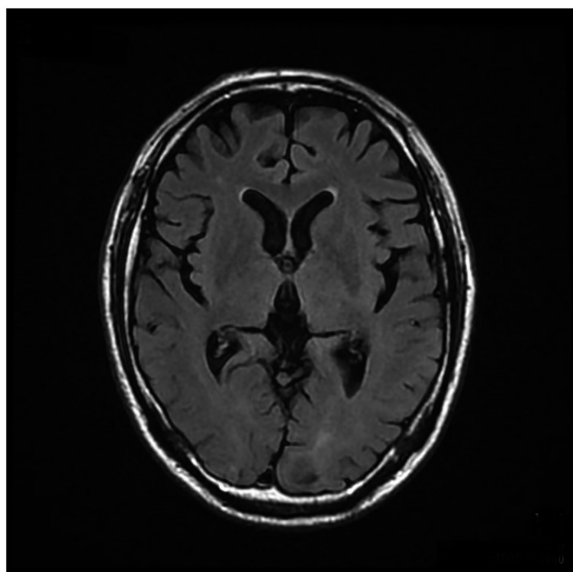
Brain magnetic resonance imaging findings (horizontal section). Cerebral cortex atrophy was not noted. There were no findings of high intensity in the hippocampus region, nor were there findings suggesting ischemia in the DWI.
